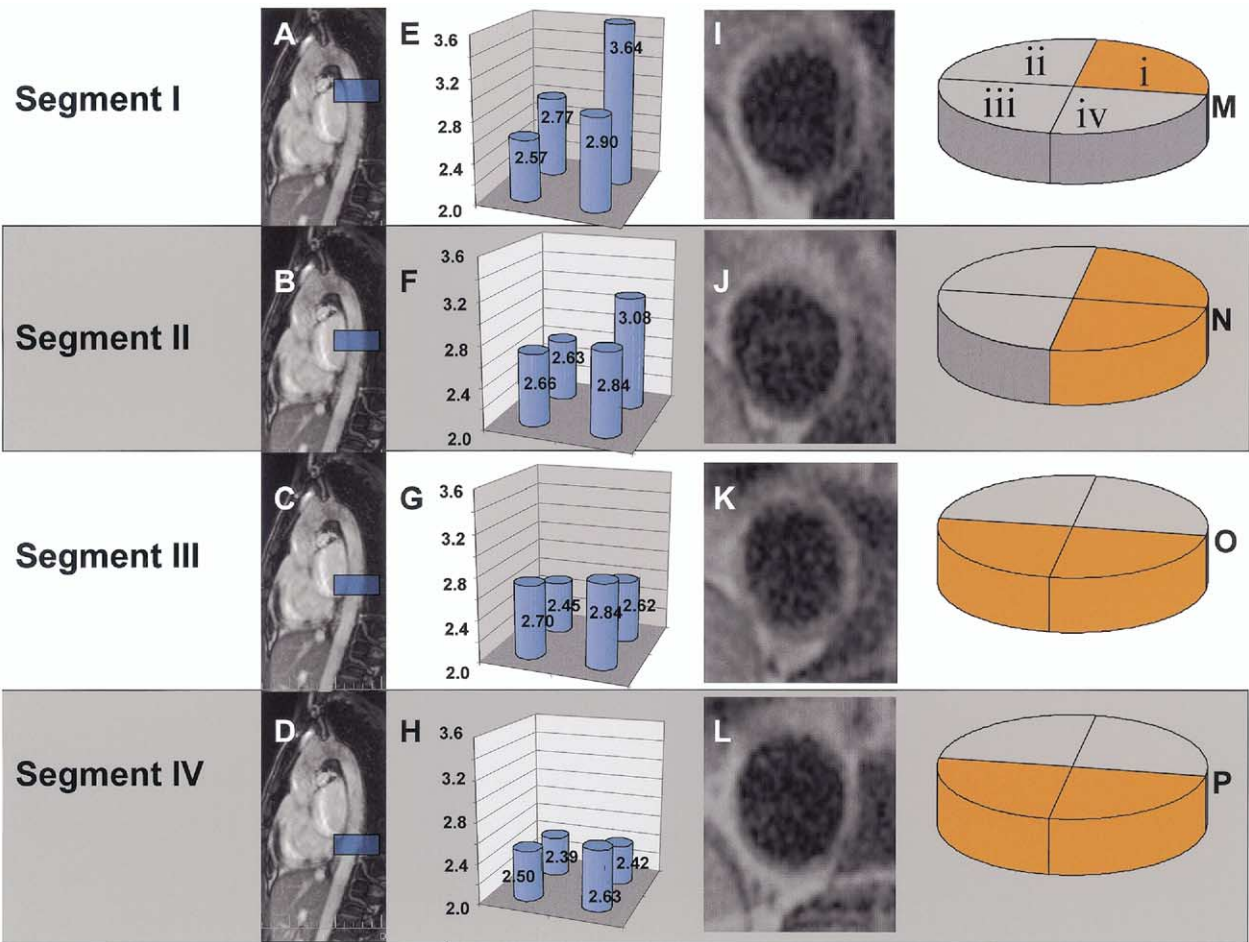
Plaque distribution depending on axial and circumferential location (A to D) location of segments I to IV on magnetic resonance imaging overview of aorta. (E to H) Average wall thickness at baseline for quadrants i to iv for segments I to IV. (I to L) Magnetic resonance imaging cross sections of aorta of individual patient at segments I to IV. (M to P) Quadrants with an average relative wall thickness exceeding the average of the segment are shown in orange.
